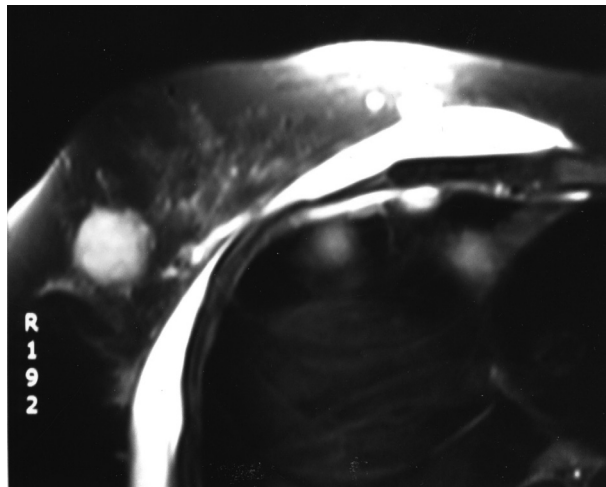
MRI (T2 sequence) showing a well demarcated, round, hyperintense, nodular lesion in the right breast suggestive (possibly) of metastatic melanoma
